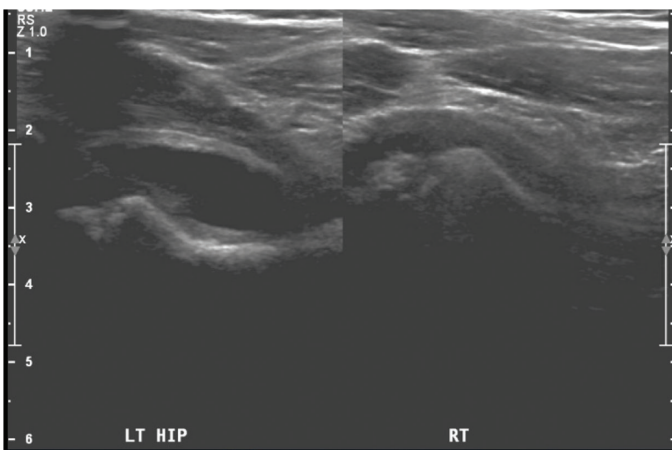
An ultrasound reveals a left hip effusion.
